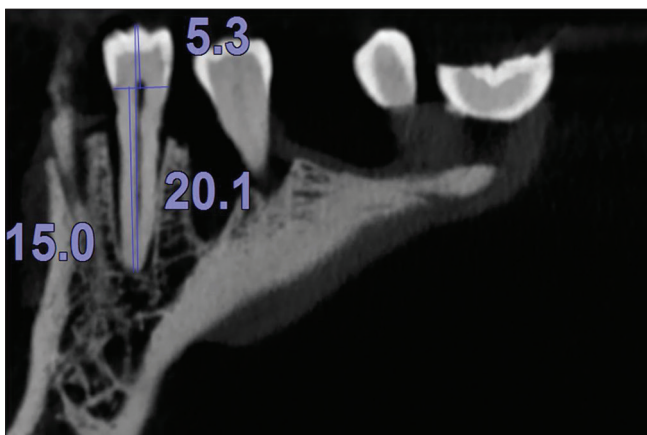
Measurement by cone-beam computed tomography
